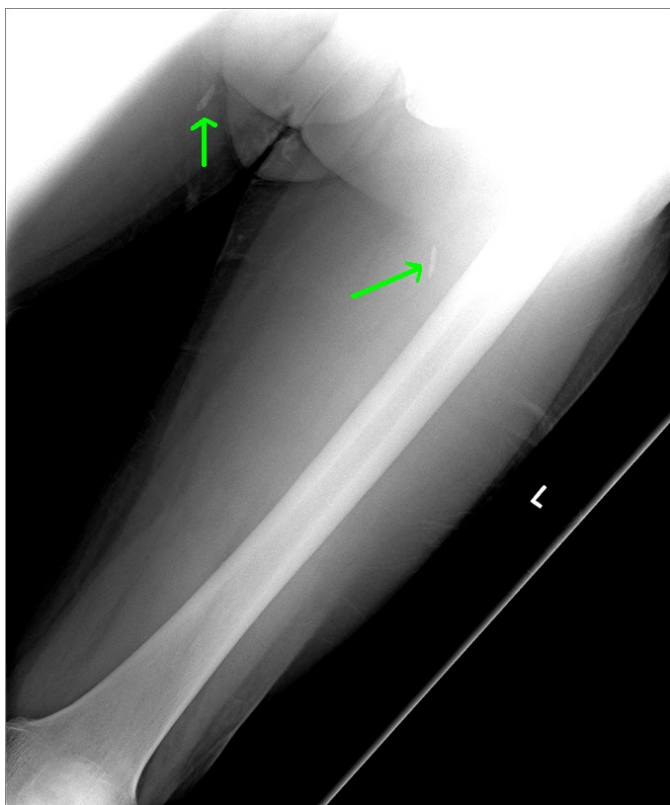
X-ray of the thigh showing the typical 'rice grain' like calcified cysticerci embedded in the thigh muscles, which are indicated by the green lines.
